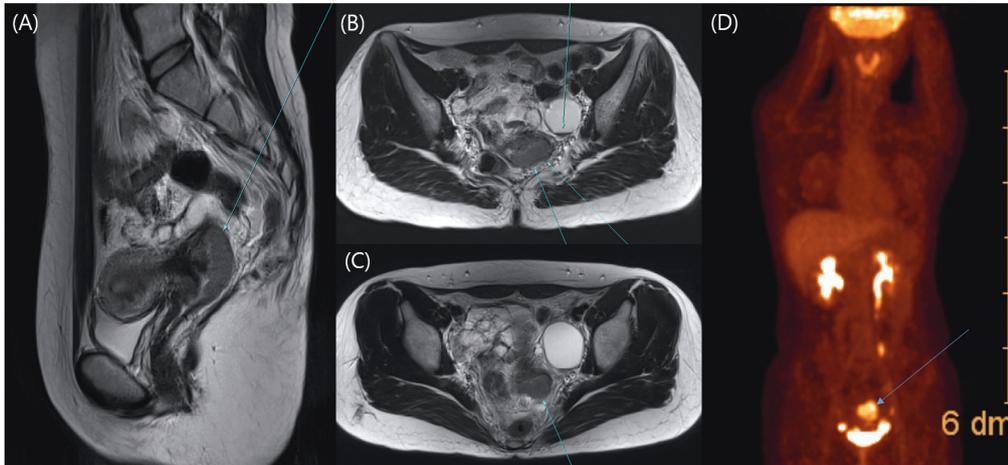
(A-C) A Pelvic MRI shows a 4-cm mass lesion at the uterine cervix with invasion of parametrium (slightly T2 high signal intensity). (D) A PET-CT is performed for metastatic cancer evaluation and it reveals an intense hypermetabolic lesion at the uterine posterior cervix.
